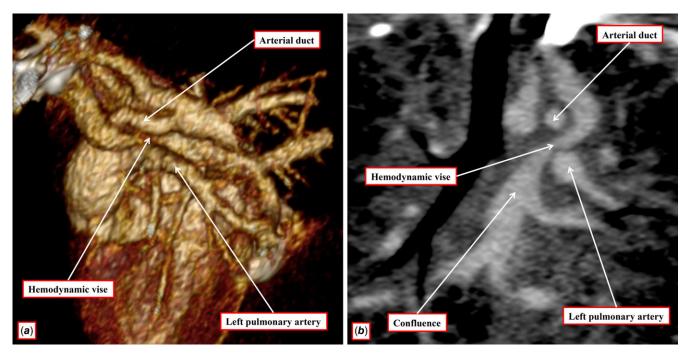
α*. Three dimensional volume rendered image of the computerized tomogram image in a left oblique projection demonstrating the site of compression (star) between the left pulmonary artery and the arterial duct. *b*. Reconstructed computerized tomogram (CT) image in the coronal plane demonstrating the compression (arrow) of the vertical vein between the left pulmonary artery and the arterial duct.
